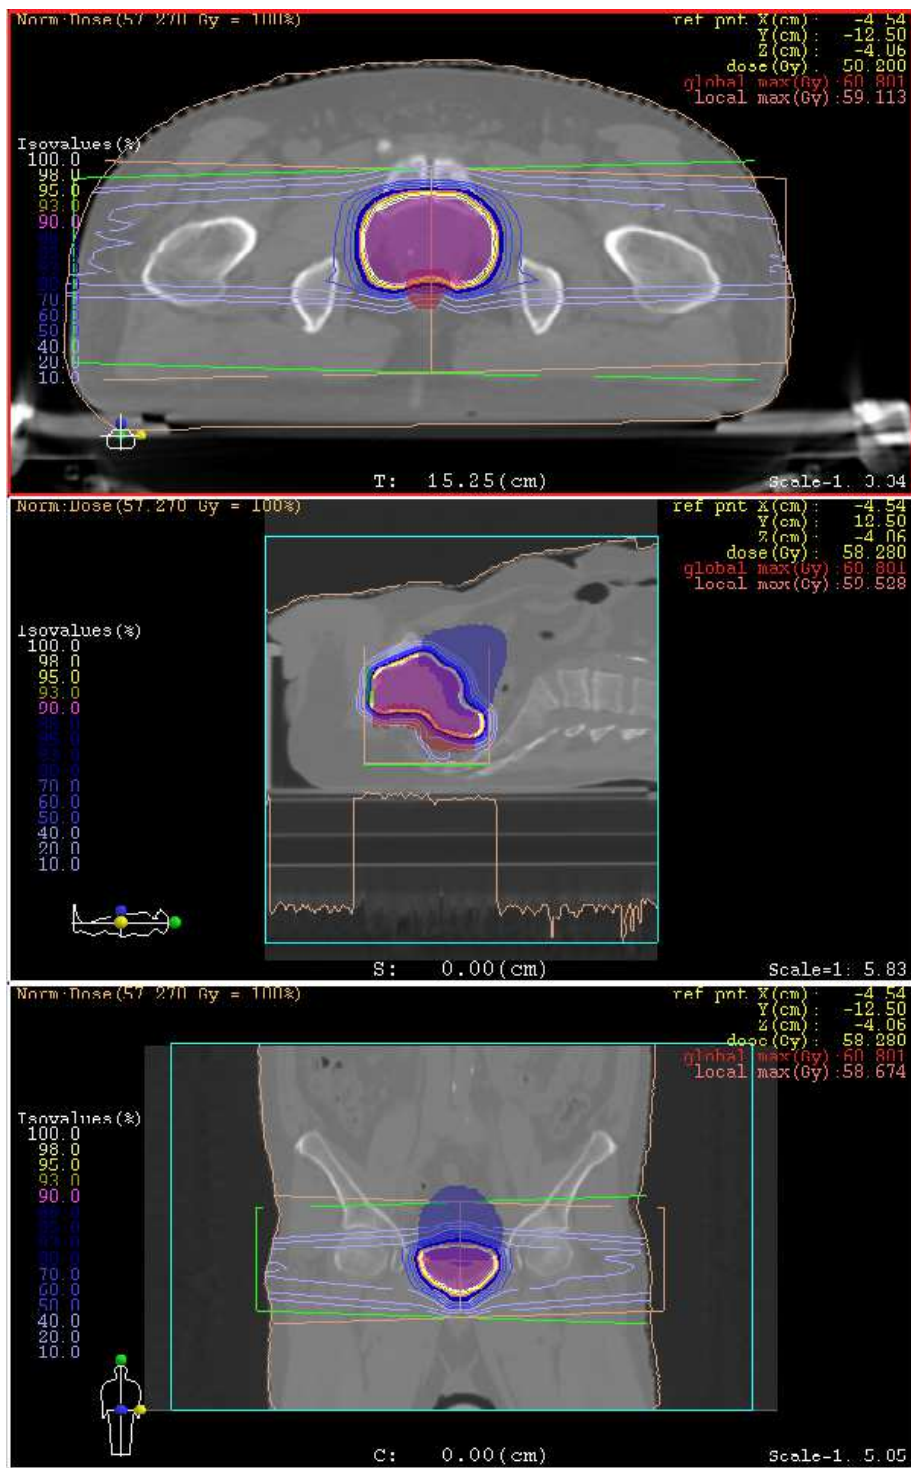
Images from XiO TPS that show the two beams applied to the patient CT and the resulting isodose curves.
